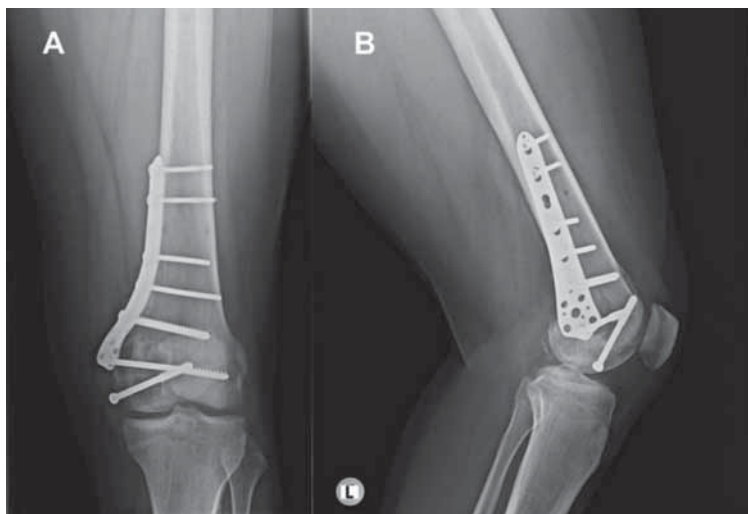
Radiographs of the left knee after definitive fixation with a single low-contact medial plate: (A) anteroposterior view; (B) lateral view.
